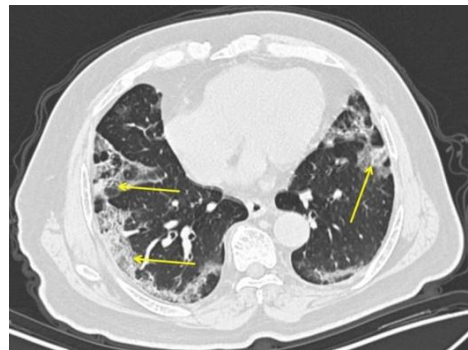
CT scan showed bilateral diffuse infiltrates with areas of consolidation and extensive ground-glass opacities
